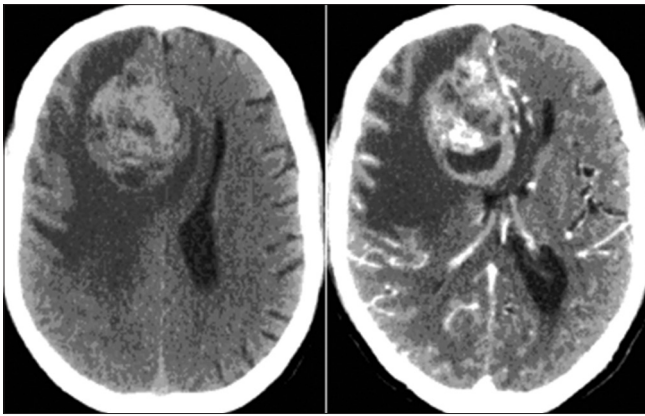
Computed tomography scan of brain (plain and contrast)
